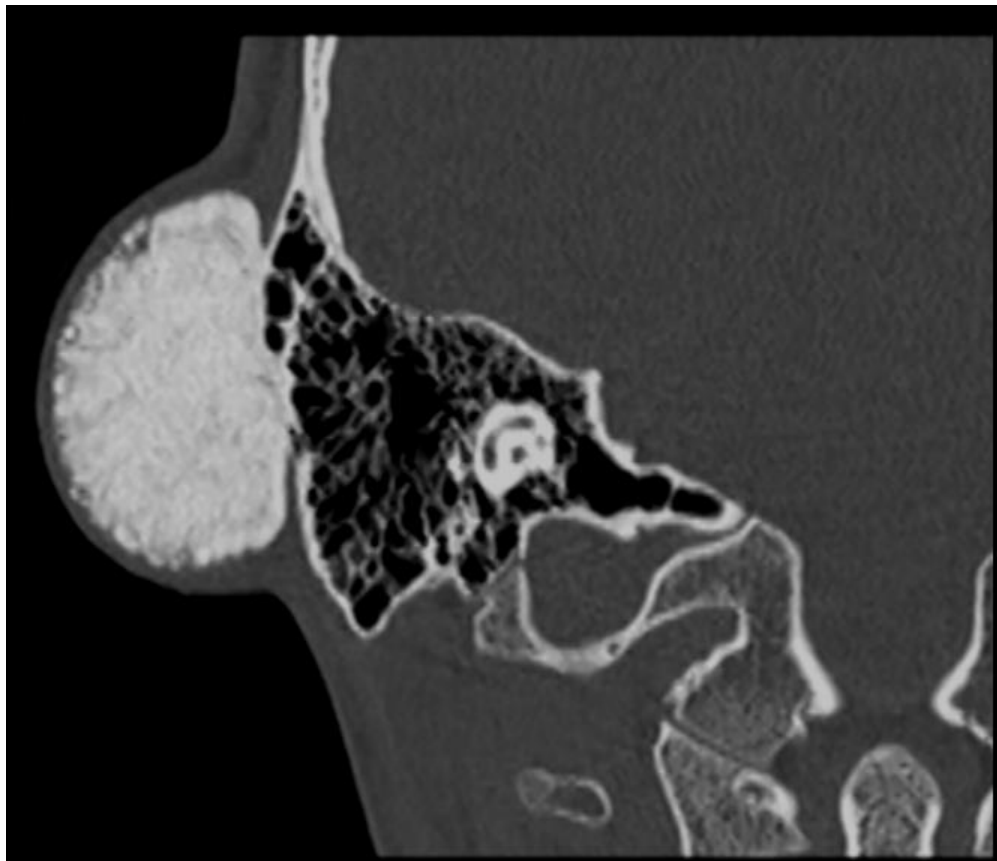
Axial CT Scan image showing the round osteoma on the outer surface of the mastoid on the right side.
